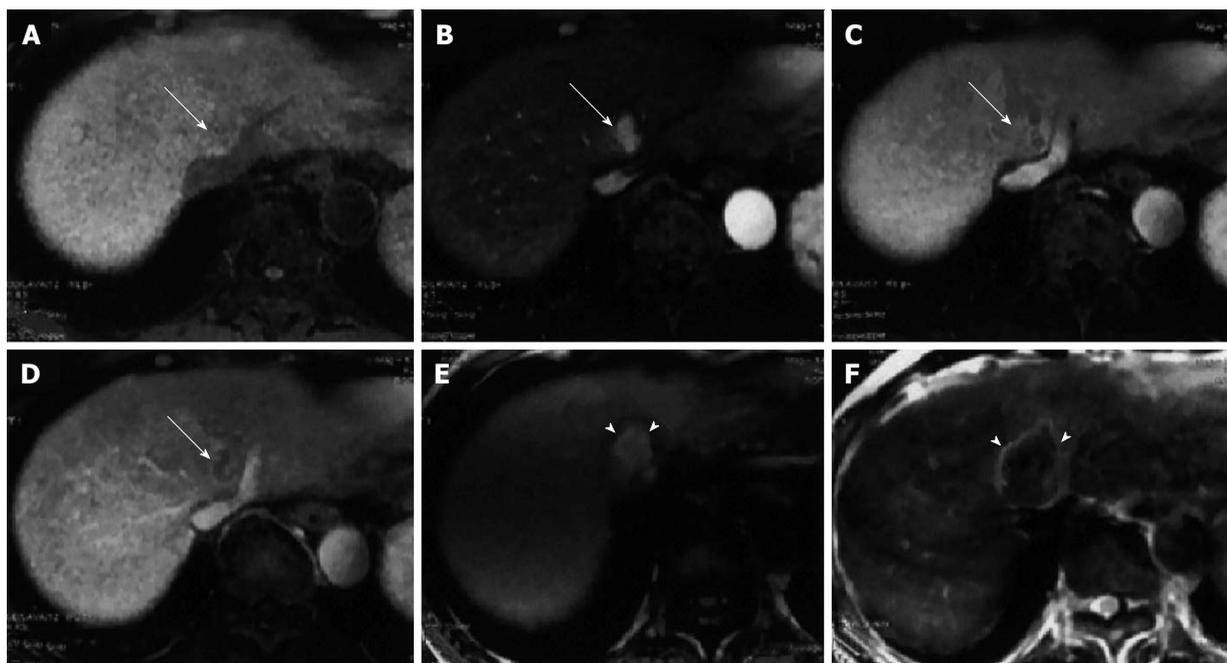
Dynamic magnetic resonance imaging of hepatocellular carcinoma. A: Precontrast; B: Arterial phase; C: Portal venous phase; D: Equilibrium phase; dynamic magnetic resonance imaging obtained with the LAVA sequence prior to therapeutic treatment. The hepatocellular carcinoma (HCC) (arrow) is seen adjacent to the hepatic vein as an enhanced nodule in the late arterial phase and as hypo-attenuated nodule in the portal venous and equilibrium phases; E: T1-weighted gradient echo image; F: Spin echo T2-weighted image two days after radiofrequency ablation therapy for HCC. The completely ablated area shows as hyperintense on T1-weighted images and as hypointense on T2-weighted images (arrowheads)^[66].
